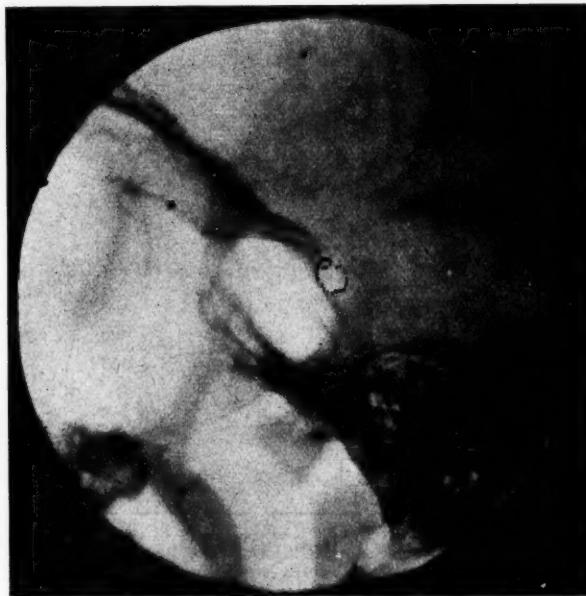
x-Ray of sella of Case I, aged eight and a half years. The sella is decidedly small.
